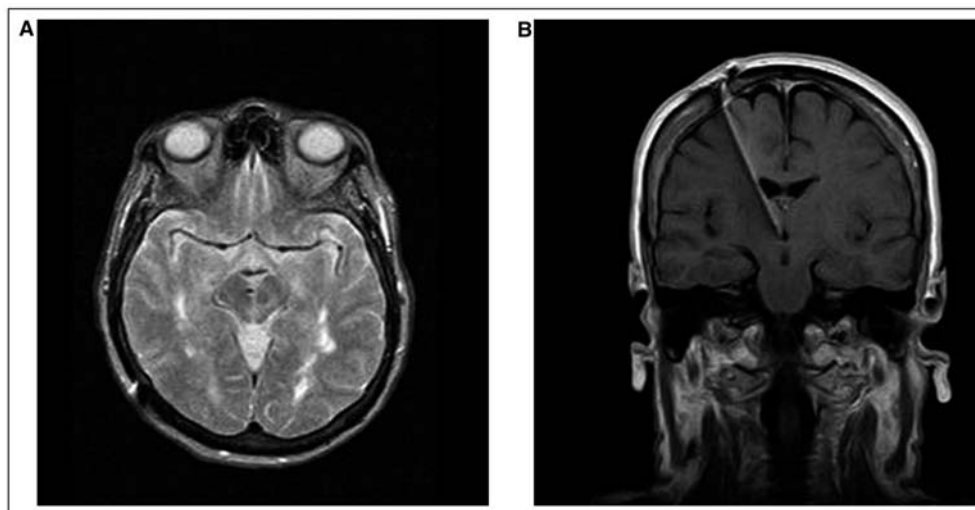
Postoperative MRI scans of a trigeminal neuralgia–multiple sclerosis (TN-MS) patient. (A) MRI T2-weighted axial image shows the deep brain stimulation (DBS) lead in the posterior hypothalamus (pHyp) of a TN-MS patient. Note the presence of signal abnormalities in the supratentorial periventricular white matter. (B) MRI T1-weighted coronal scan showing the lead.
